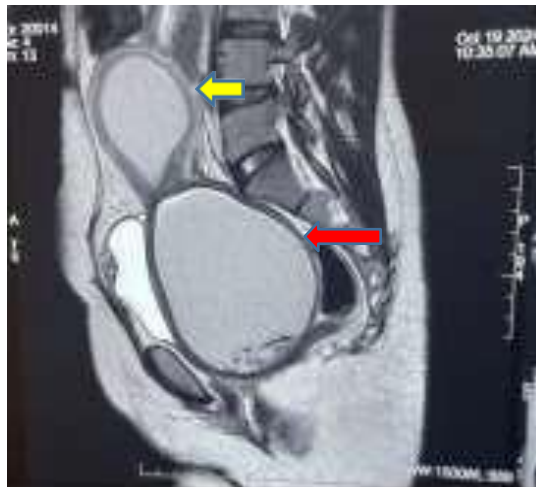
MRI picture showing hematometra (yellow arrow) and hematocolpos (red arrow).
